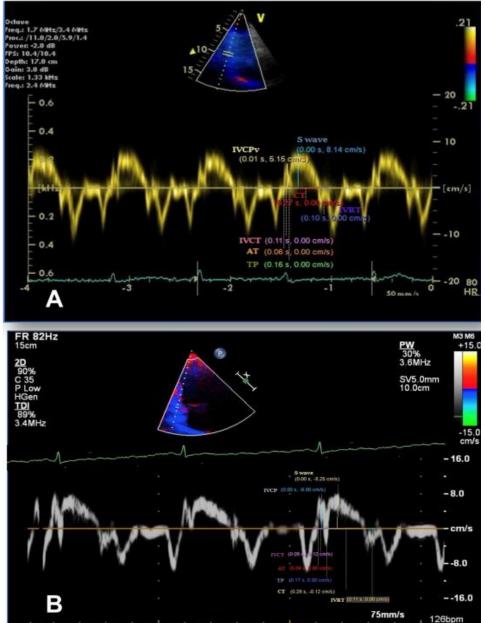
A, B. A case of occlusion-RCA before (A) and after Percutaneous coronary intervention, (B) tissue Doppler imaging (TDI): shows changes in TDI parameters values before and after PCI in basal inferior wall.
